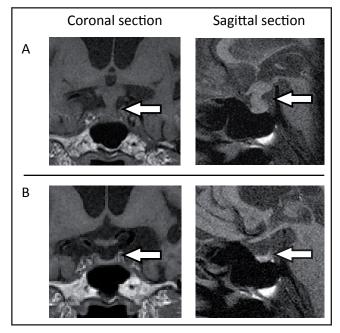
Cranial MRI (Non-enhanced T1-weighted image). A) Day 0; B) Day 12. The left panels are coronal sections and the right panels are sagittal sections. The arrows indicate the marked swelling of the pituitary gland and the tubeloinfundibular stalk on Day 0 (A) and the empty sella on Day 12 (B). A high intensity of the neurohypophysis was absent throughout.
